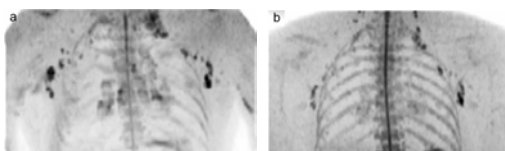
Coronal MIP images of STIR DWI of a patient with multiple lymph node metastases (a) at 3.0 and (b) at 1.5 Tesla. A better lesion-to-surrounding tissue (spinal cord, vertebral bodies, ribs) contrast can be noted at 3.0 Tesla (a) as compared with 1.5 Tesla (b).
